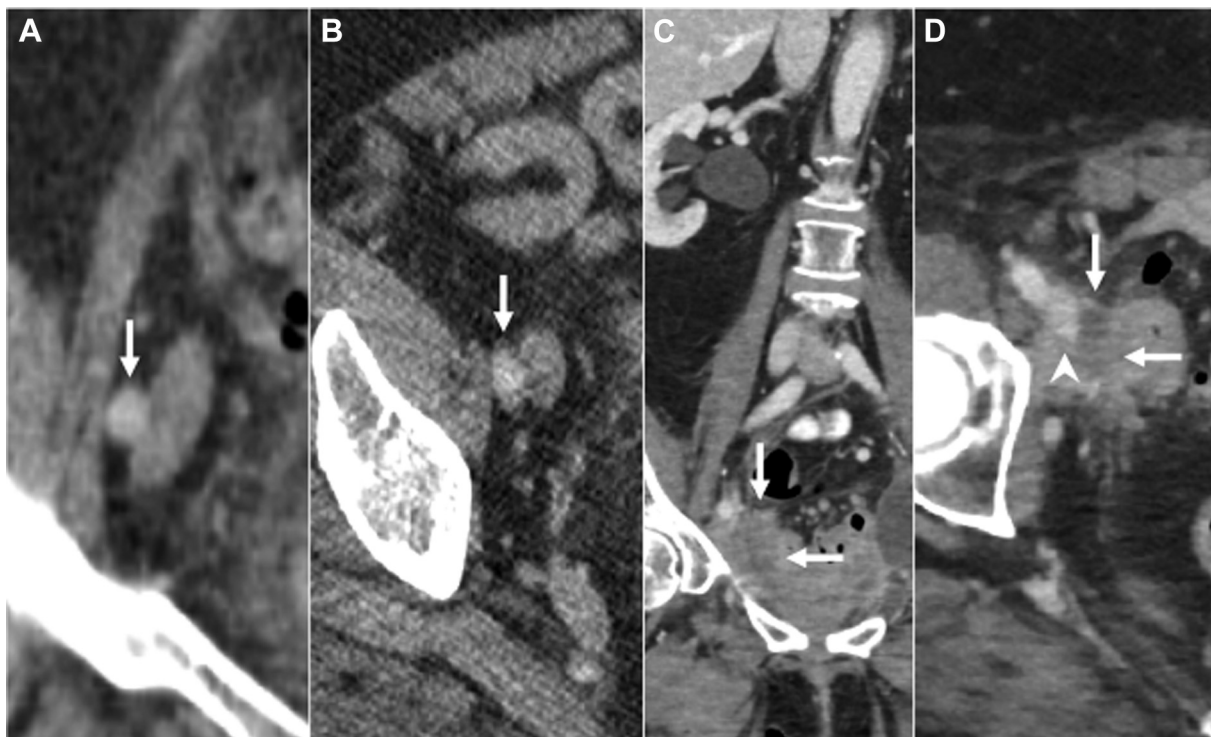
Computed tomography (CT) scan with administration of intravenous contrast 3 weeks before stent reconstruction. A, Coronal and (B) axial reformations showing a patent right external iliac artery (EIA) (*arrows*) traversing the site of metastatic recurrence along the right pelvic sidewall. C, Coronal and (D) axial reformations showing complete effacement of the right external iliac vein (EIV) at the site of metastasis (*arrows*). There is tumor encasement of the EIA and EIV and abutment of the iliac body creating a rigid confined space. At this time, there is normal opacification of the EIV immediately peripheral to the tumor (*arrowhead*) without evidence of thrombosis.
